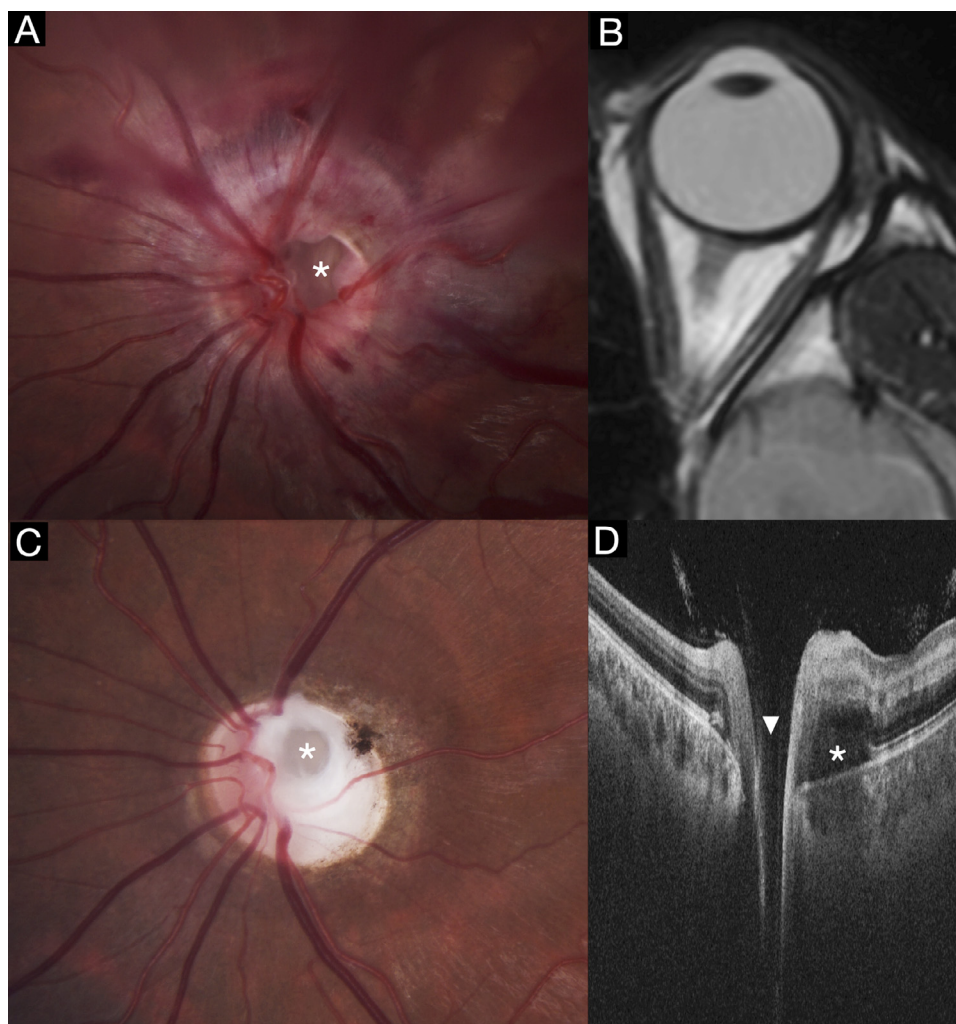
(A). Baseline Fundus Photography: Peripapillary mild vitreous hemorrhage, optic disc hyperemia, round cavity in the temporal area of the ONH (asterisk), and peripapillary intraretinal hemorrhage; B. Baseline MRI Orbits: Axial T2 image demonstrating normal left nerve globe junction; C. One Year Follow-Up Fundus Photography: Temporal ONH pallor with central round-gray defect (asterisk), and peripapillary atrophy; D. Baseline Swept-Source Optical Coherence Tomography: Cross-sectional image through the ONH cavity in (A) demonstrating subretinal fluid in the temporal peripapillary area (asterisk), and an optically empty deep cavity corresponding to the avulsion area (arrowhead), with presumed lesion of the lamina cribosa.
